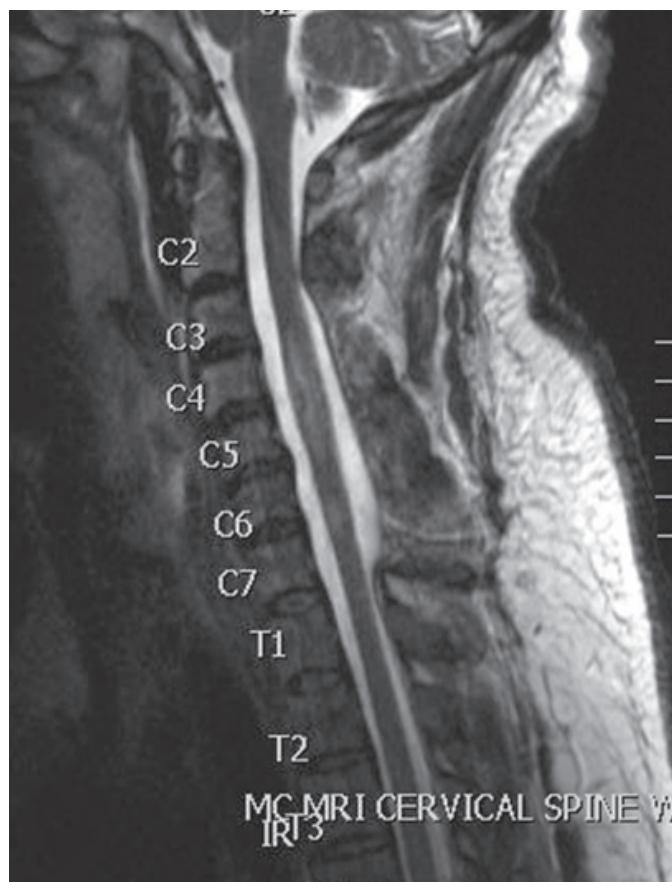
Post-surgery sagittal cut MRI C-spine.
